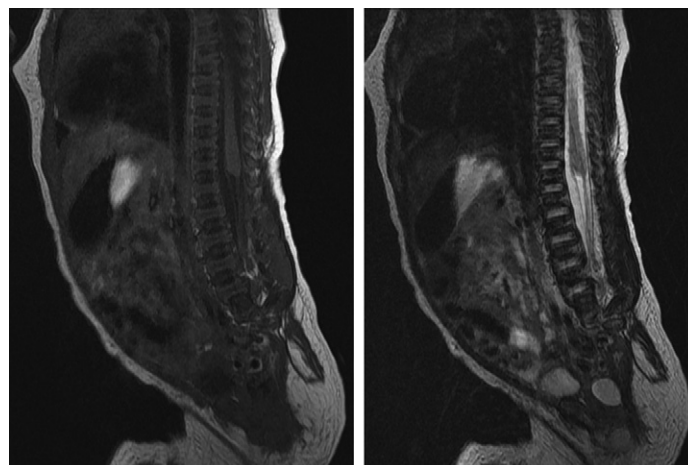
Sacral agenesis. Magnetic resonance imaging scan T1- and T2-weighted confirms complete agenesis of sacrum below S1 segment. Spinal cord is truncated and cone-shaped, with a thick filum terminale and an abnormal cyst posterior to the bladder. (Image courtesy of Vikram Dogra, M.D.)
